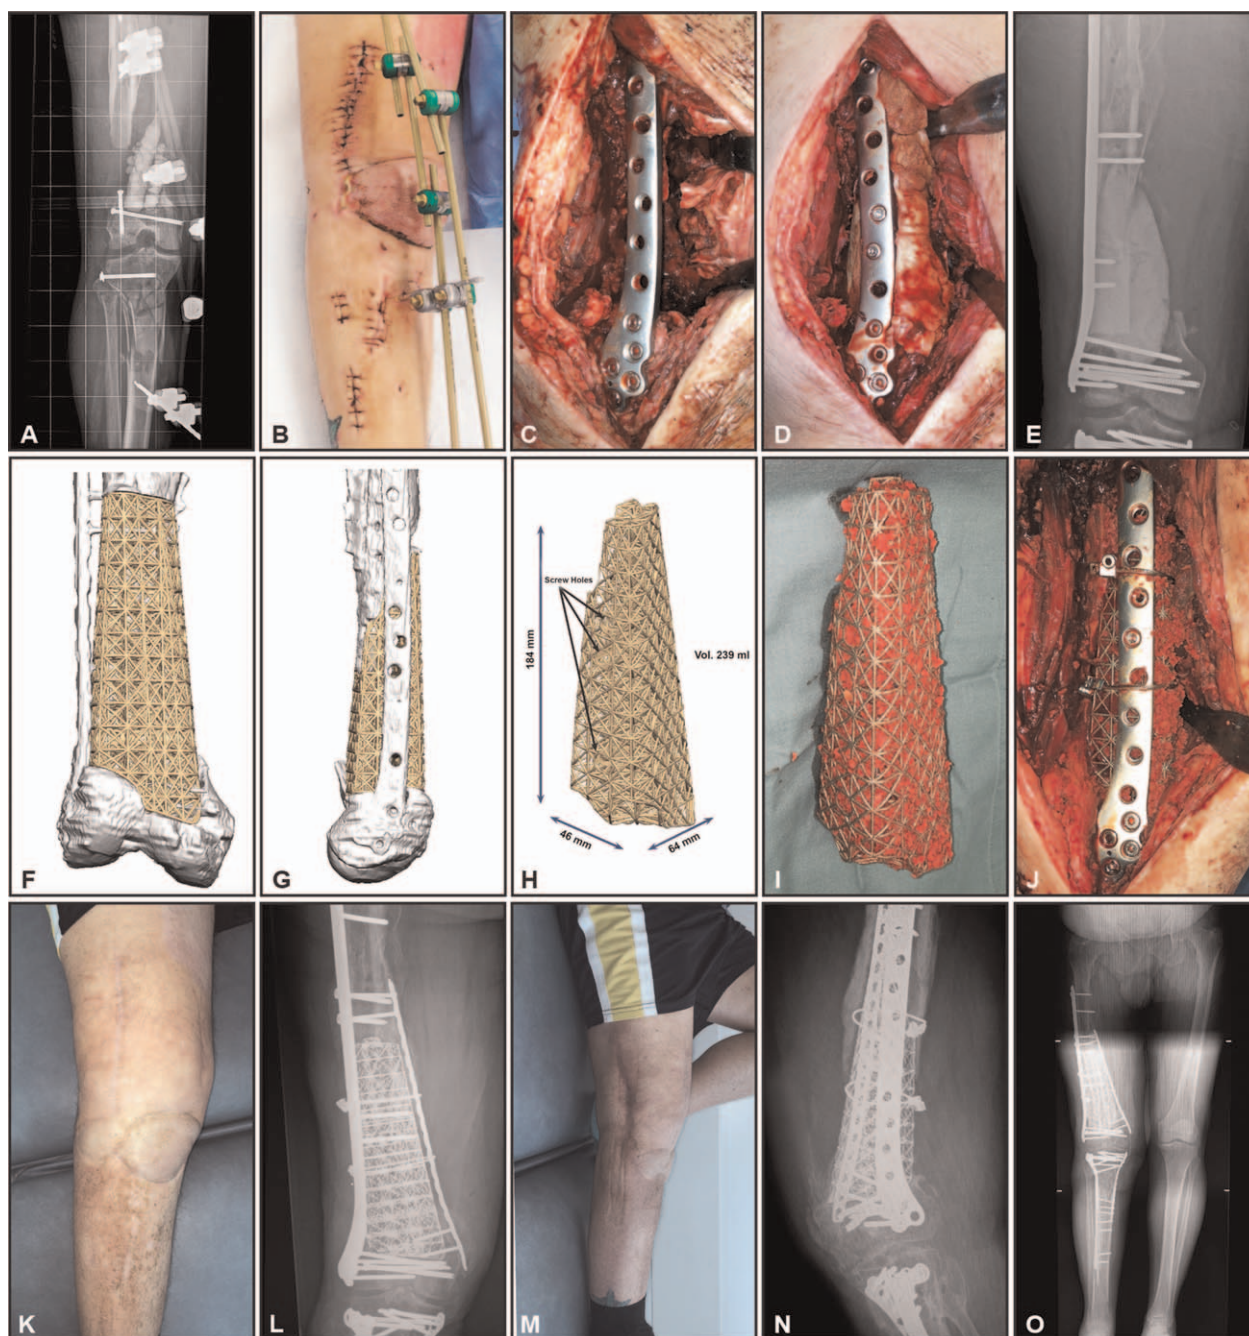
Intrahospital transfer of a 56 year old man with past medical history of smoking and obesity, who sustained polytrauma riding a motorbike struck by a pickup truck in regional Australia. His orthopaedic injuries were largely restricted to a right “floating knee”. These fractures included: (i) closed metadiaphyseal fracture of the right proximal tibia with intra-articular extension; (ii) a comminuted right patellar fracture; and (iii) a high-energy Gustilo grade 3B open intra-articular fracture of the right distal femur with segmental bone loss and absent cartilage. (A) Anterior-posterior radiograph following emergency irrigation and debridement, limited screw fixation of intra-articular elements, and spanning external fixation locally before transfer to tertiary care facility; (B) open wound overlying right knee urgently covered with a medial gastrocnemius rotational myoplasty, seen here 3 weeks later; (C) intraoperative photograph of the 15cm segmental defect after further debridement, return to length, and stabilization with a lateral locked plate; (D) intraoperative photograph of an antibiotic loaded PMMA spacer used to temporarily reconstruct the defect, a variation of the Masquelet technique; (E) Postoperative anterior-posterior radiograph of the temporary construct, with a lateral locked plate and PMMA antibiotic spacer in situ; (F) anterior view of the design proposed for a truss-type titanium cage to reconstruct this defect; (G) lateral view of the design proposed for this truss-type titanium cage implant; (H) detailed specifications for the truss-type titanium cage, 18.4cm in length after allowing for additional bone resection to enhance the stability of the construct; (I) intra-operative view of the 3D printed patient-specific titanium cage, packed with morselized allogeneic and autograft cancellous bone; (J) intraoperative photograph of the definitive reconstruction of the defect, demonstrating modification of internal fixation with addition of cables and a medial plate not visible here; (K) clinical photograph of the right knee and lower extremity 10 months postoperative, demonstrating benign appearance of the flap; (L) Anterior-posterior radiograph of the right distal femur 10 months postoperative, demonstrating the medial plate further augmenting stability; (M) clinical photograph of the right knee and lower extremity 10 months postoperative, demonstrating small flexion contracture; (N) lateral radiograph of the right distal femur 10 months postoperative; (O) long-standing radiograph of both lower extremities 10 months postoperative, demonstrating 2.2° valgus and a residual 23 mm limb length discrepancy (LLD). Patient’s clinical outcome was the most inferior in this series, with a final range of motion of the knee of only 10–75°. Patient’s age, patella fracture, loss of articular cartilage, the need for soft tissue coverage with a flap, and the severity of the injuries sustained almost certainly all contributed to the sub-optimal outcome achieved.
